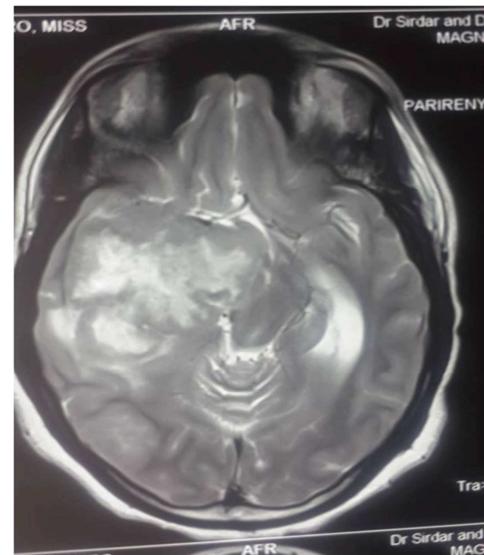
MRI Scan of Brain showed multiple lobulated irregularly enhancing brain parenchymal mass lesions of variable sizes, the big mass has bright signal intensities at T1, T2 and shows aswell speckles of some calcifications within the mass.
